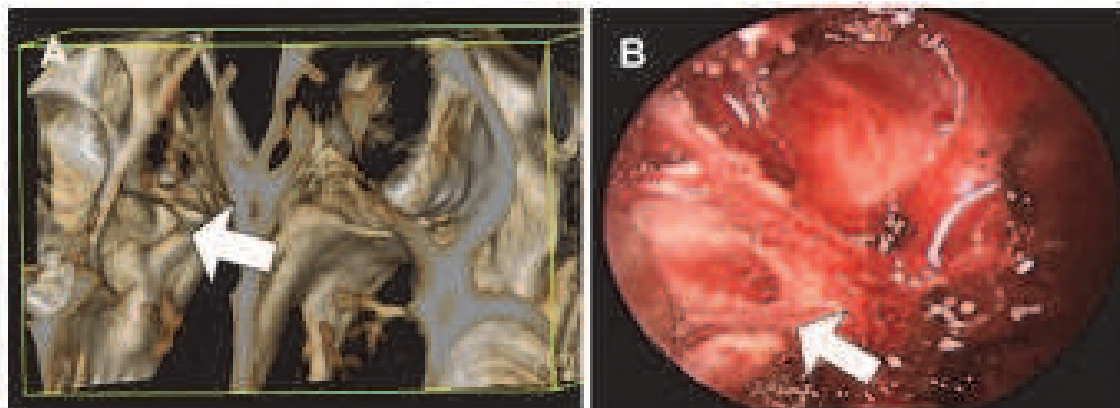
The gap (arrow) between the sphenoid sinus anterior wall and the pterygoid process or the SPP is demonstrated on A: pre-operative 3D reconstruction CT image; B: intraoperative endoscopic view.
